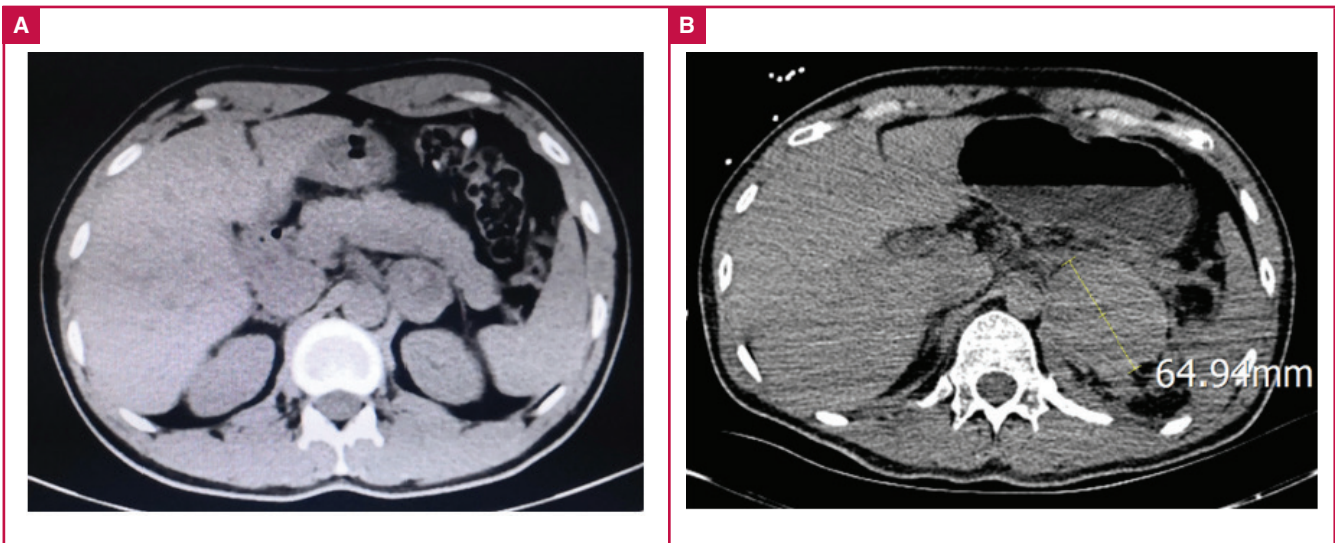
A. The first computed tomography (CT) on admission showed a 3.7-cm mass of uneven density in the left adrenal gland. B. The second CT revealed the mass had expanded to 6.5 cm in diameter, with accumulation of fluid surrounding the left pararenal and parapancreatic space.
